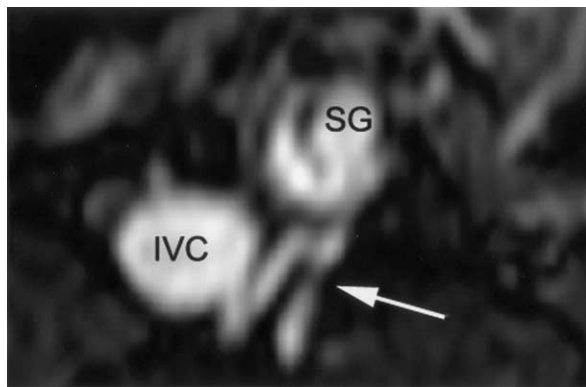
Magnetic resonance image with gadolinium enhancement of retrograde (type II) endoleak. Paired lumbar arteries (*arrow*) are visualized perfusing the aneurysm sac in a retrograde manner. Stent graft (SG) is seen within the aneurysm sac. Inferior vena cava (IVC) is also visualized.
